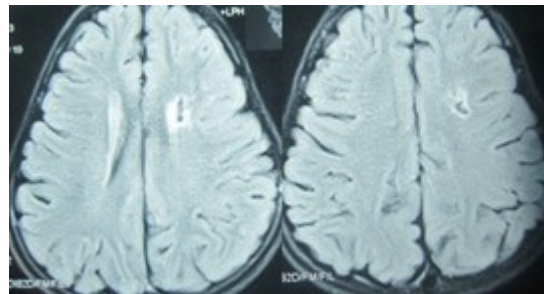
MRI of brain FLAIR axial views showing left frontal subcortical gliosis causing focal seizures. Source: Figure by authors.
